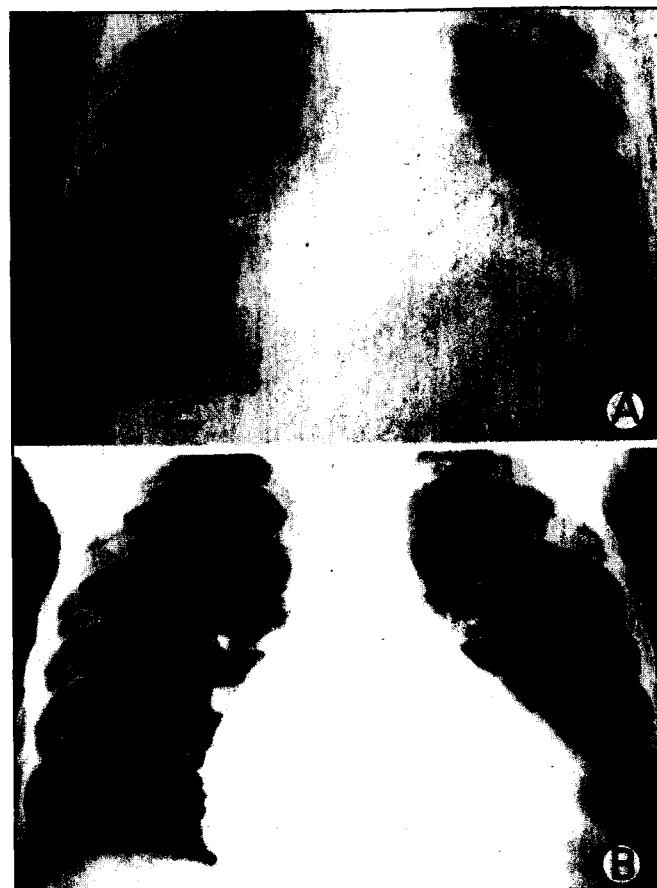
Patient No. 12. Thorax X-rays in frontal projection, before (A) and after (B) L-carnitine treatment for three months. A: an important heart enlargement and signs of pulmonary venous-capillary hypertension. B: a moderate reduction of cardiomegaly, and no pulmonary venous-capillary hypertension are observed. This figure is reproduced from the volume "Role of L-carnitine in cardiomyopathies in infancy-presented in the World Congress of Pediatric Cardiology and Cardiac Surgery, Paris, June 21-25, 1993, with the kind authorization of Dr. J. P. Bonnefont of the Hôpital Necker enfants-malades of Paris, and Sigma Tau of Rome.
